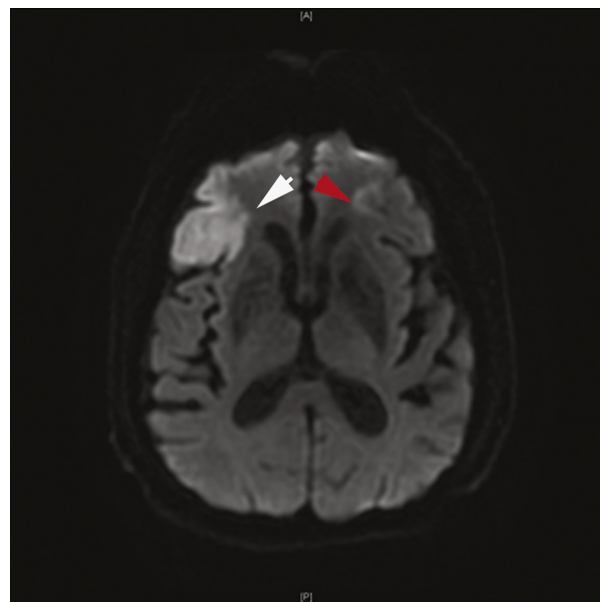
Axial diffusion-weighted MRI of the brain taken July 2011 indicated a 3.5-cm infarction in the right frontal lobe (white arrow, left) and ischemic change in the left frontal-parietal region (dark arrow, right). Minor evidence of ischemia was seen bilaterally in the insula, pons, cerebellum, and occipital cortices.
